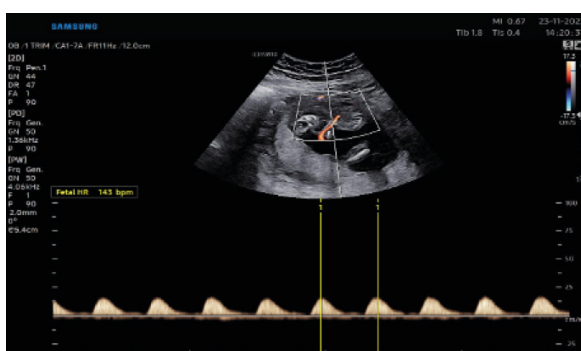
Color and spectral Doppler of the umbilical artery (acardiac twin), showing reverse blood flow.
